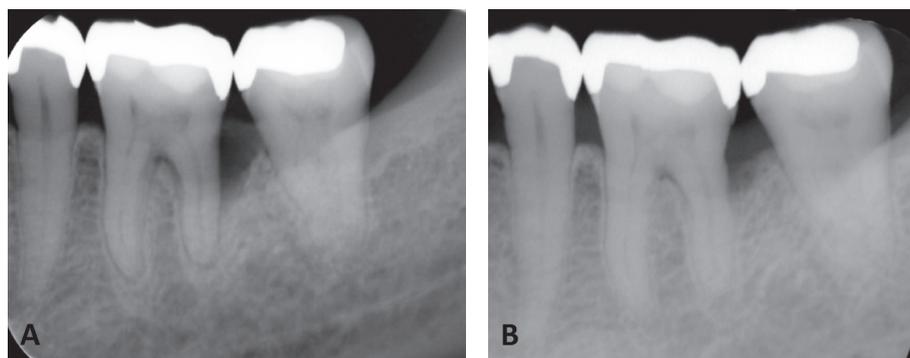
A) Pretreatment conventional intraoral radiograph of the left mandibular first molar. B) Conventional intraoral radiograph taken 8 months after periodontal flap surgery, showing regeneration of alveolar bone around the involved root.
